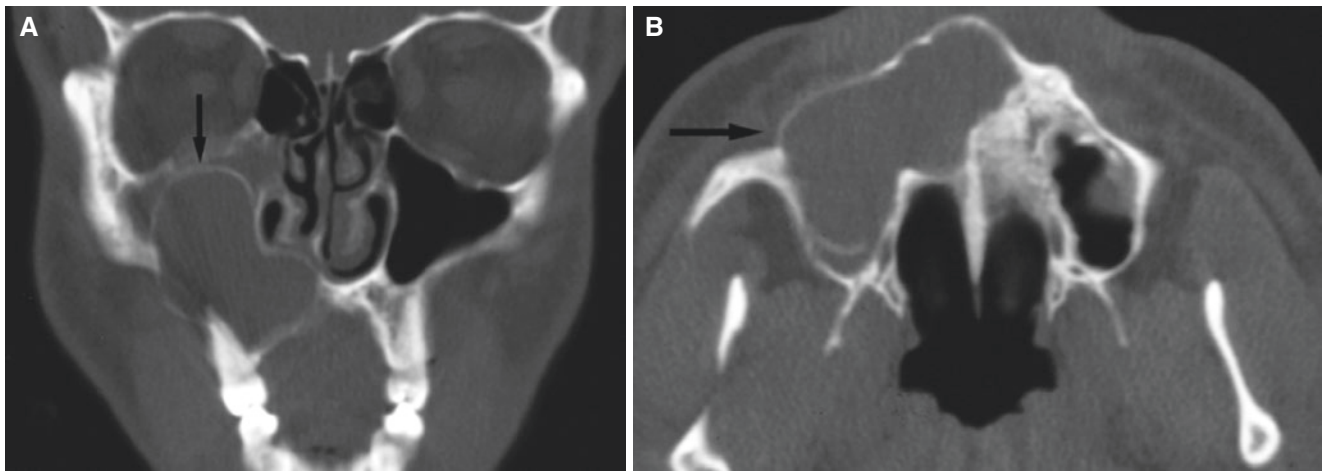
Periapical cyst, maxilla; 38-year-old male with some discomfort and swelling of mucobuccal fold; nonvital right lateral incisor. (A) Coronal CT image shows expansive process displacing part of nasal
